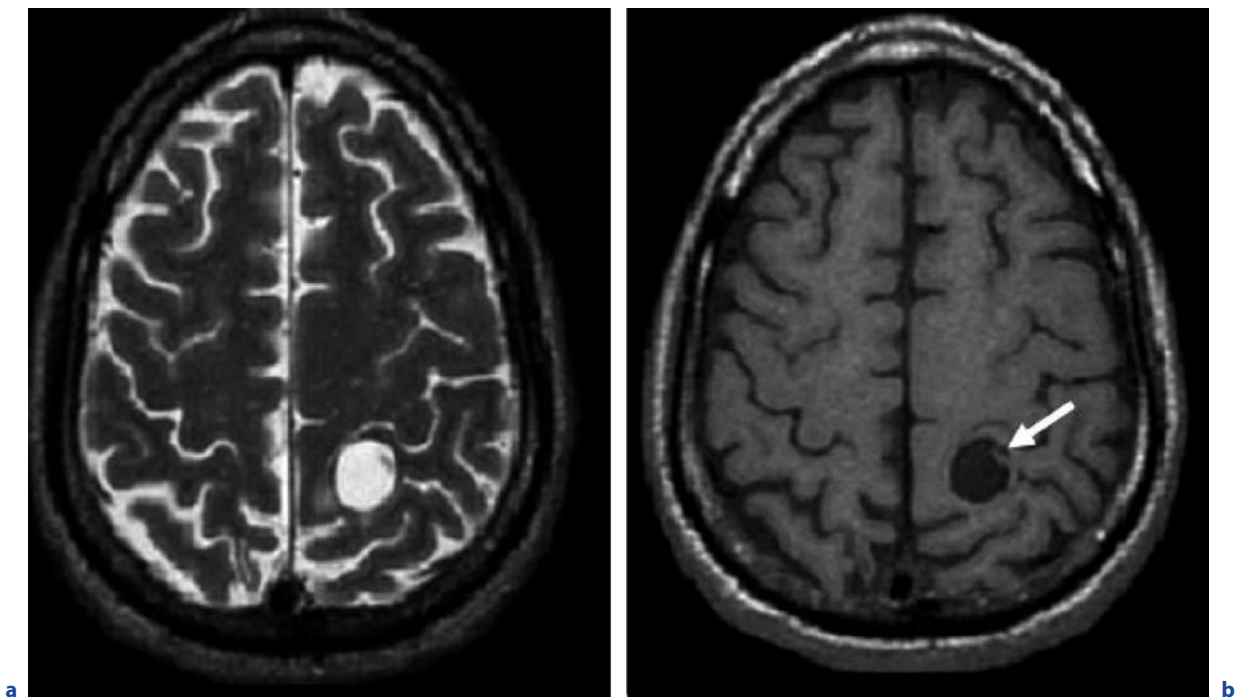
Neurocysticercosis in a 40-year-old man who presented with headache. a Axial T2-weighted image. b Axial T1-weighted image before contrast administration. c-g see next page
